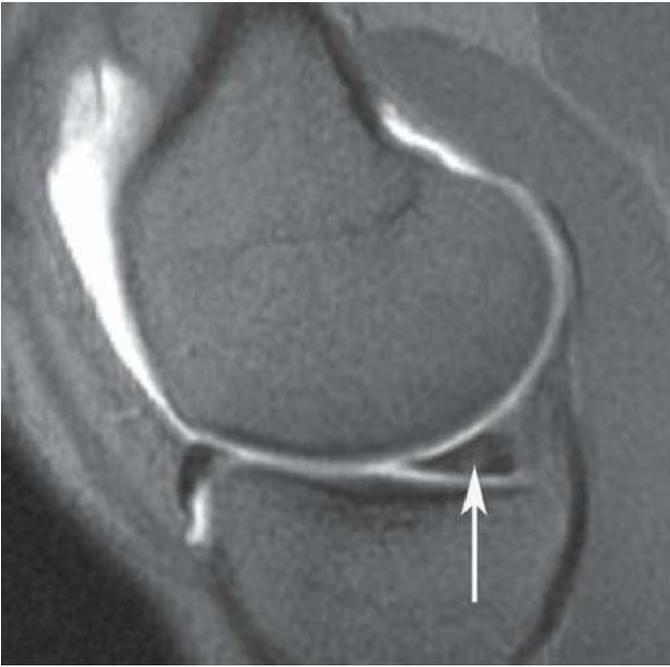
Sagittal T2-weighted MRI demonstrating high intrameniscal signal (*white arrow*) in the posterior horn of the developing meniscus.
